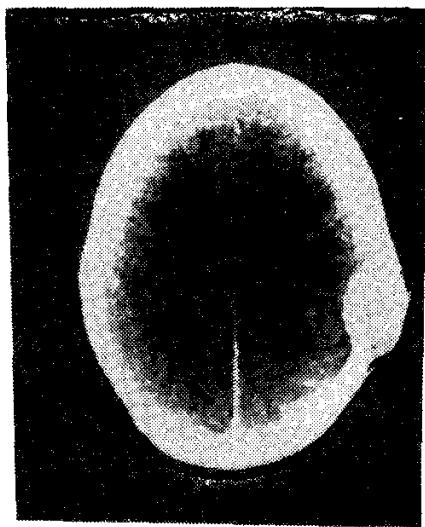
(b). Computed tomogram showing uniform enhancement of the lesion on contrast administration.
